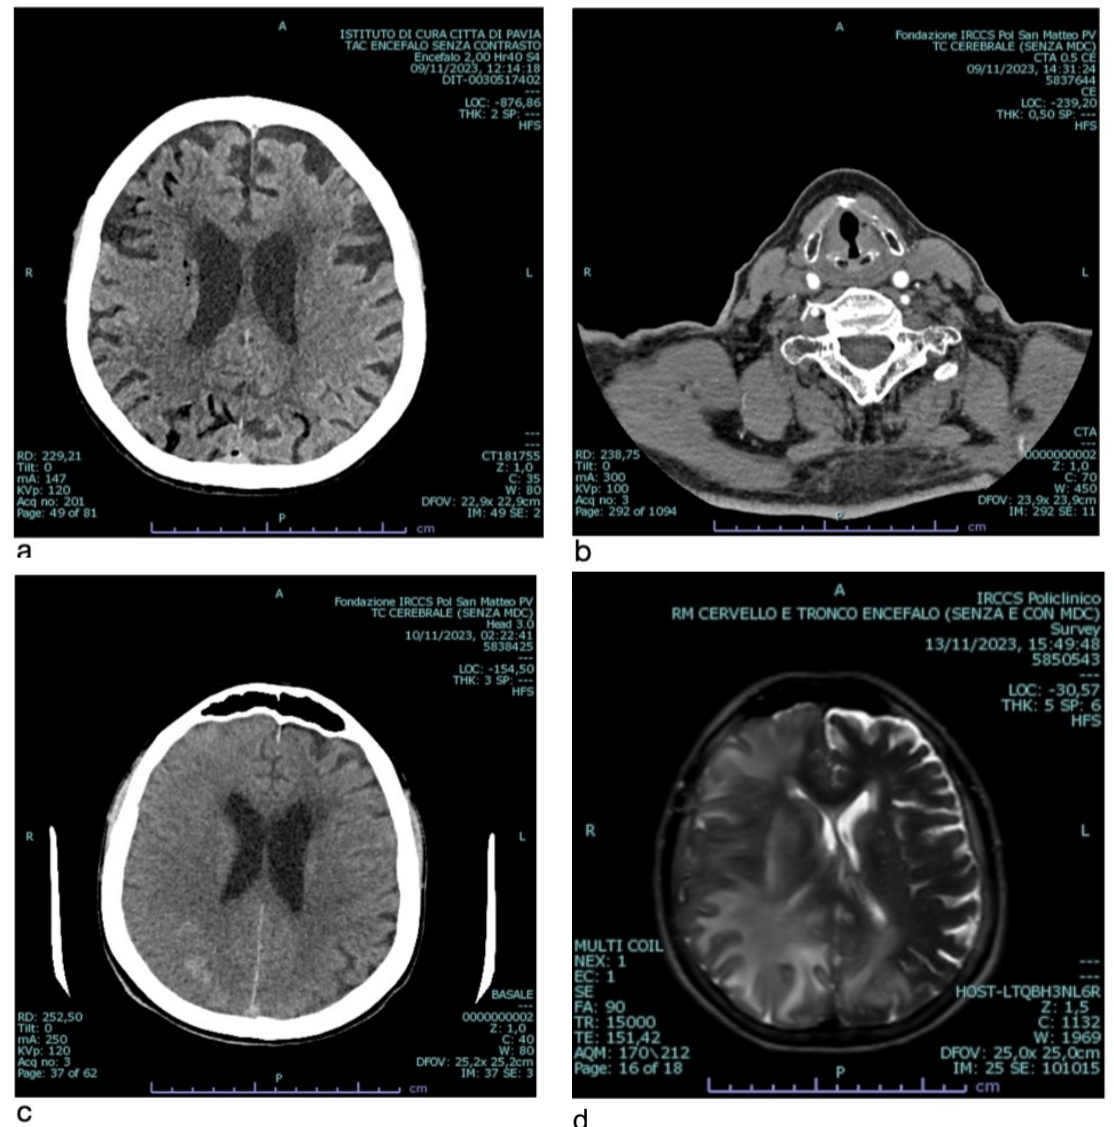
(a) Axial CT-scans without contrast and (b) CT angiography (CTA) before treatment; (c) Brain CT-scan after treatment. (d) DW-MRI Extended signal alteration located in the right fronto-parieto-occipital, involving both the cortex and the subcortical, deep, and periventricular white matter.
